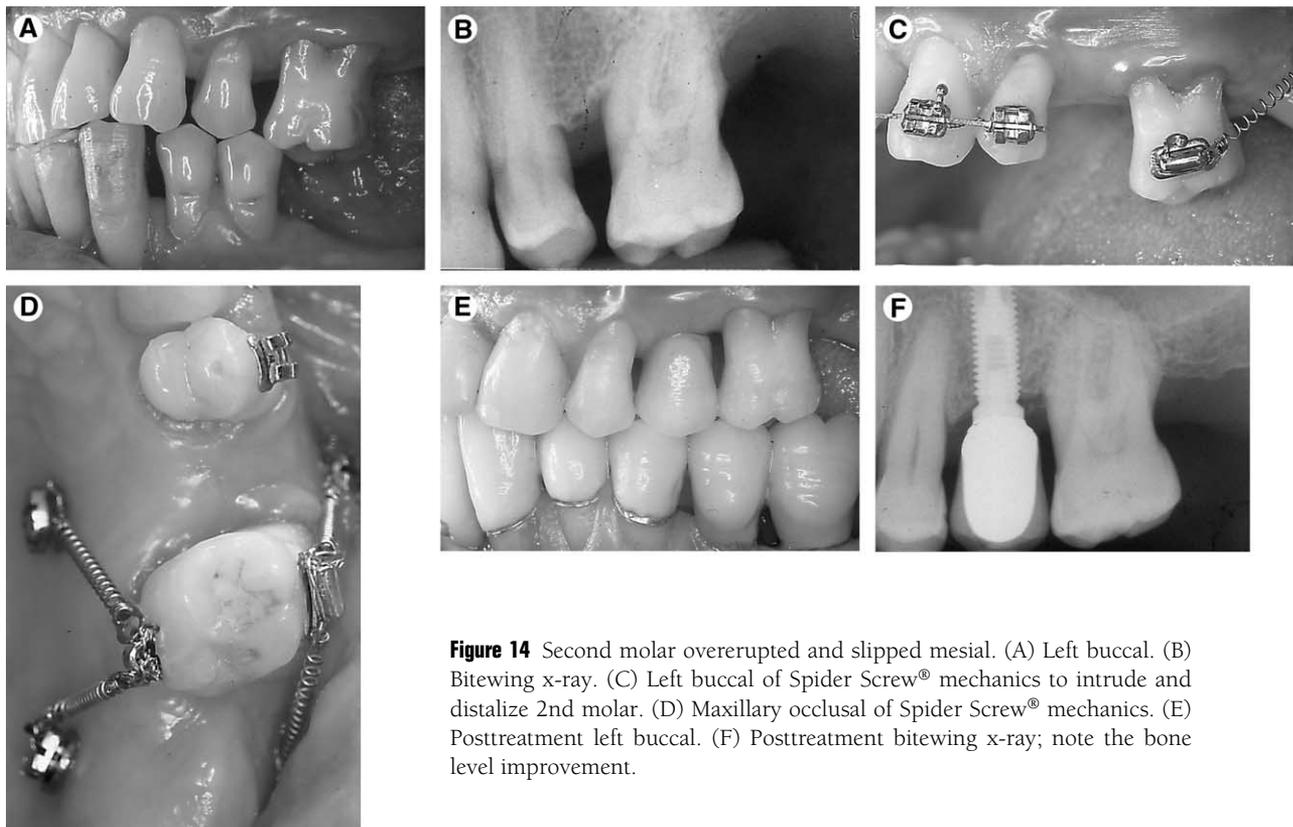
Second molar overerupted and slipped mesial. (A) Left buccal. (B) Bitewing x-ray. (C) Left buccal of Spider Screw® mechanics to intrude and distalize 2nd molar. (D) Maxillary occlusal of Spider Screw® mechanics. (E) Posttreatment left buccal. (F) Posttreatment bitewing x-ray; note the bone level improvement.
